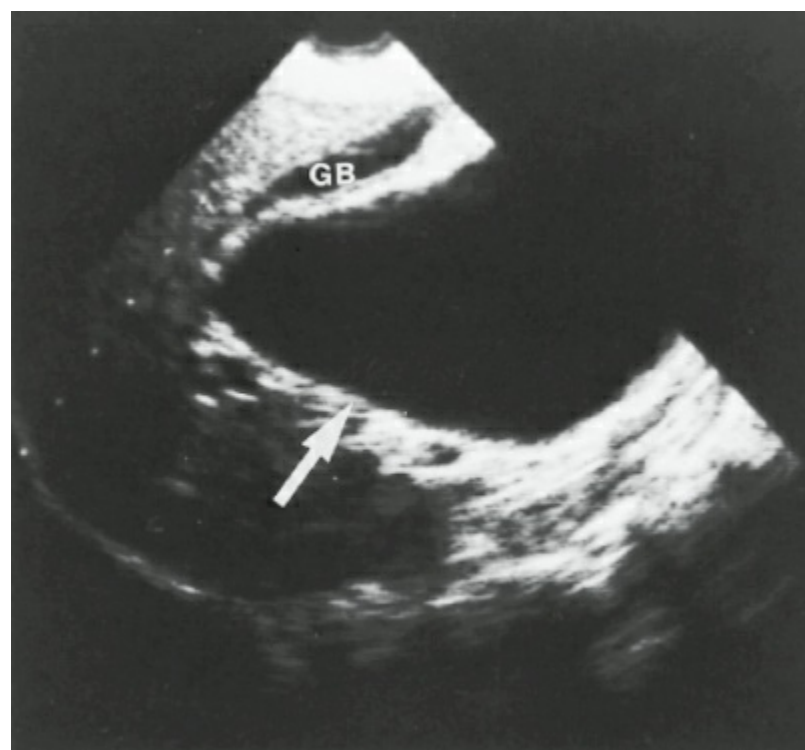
Ultrasound image of a type I choledochal cyst (arrow; longitudinal image). The gallbladder (GB) is also shown.
